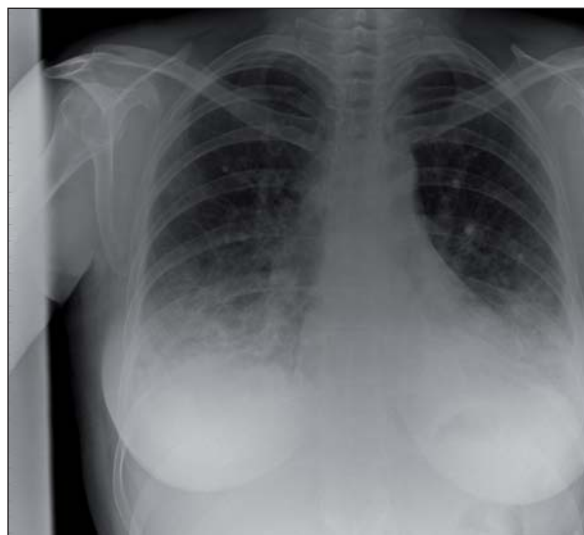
Chest radiograph showing bilateral basal fibrotic changes in a patient with systemic sclerosis.
